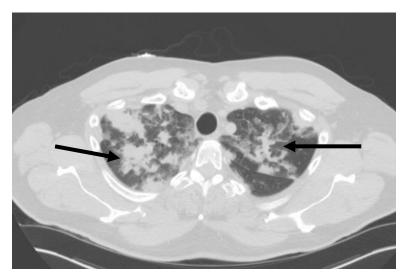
CT of the chest shows irregular, predominantly alveolar, infiltrate involving upper lobes bilaterally with lesser involvement of the lower lobes (not shown).
